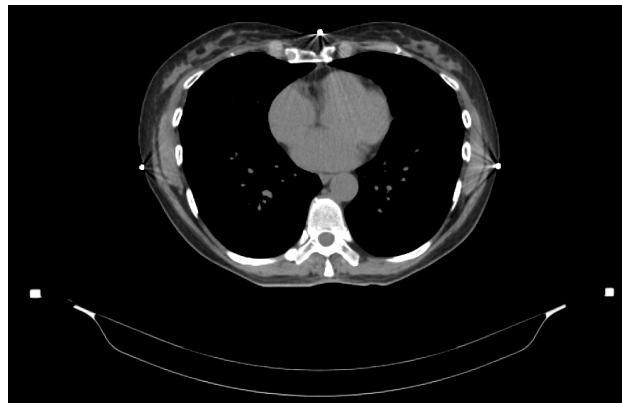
Axial CT slice displaying radiopaque skin markers, visible as distinct hyperdense dots on the patient's surface.
